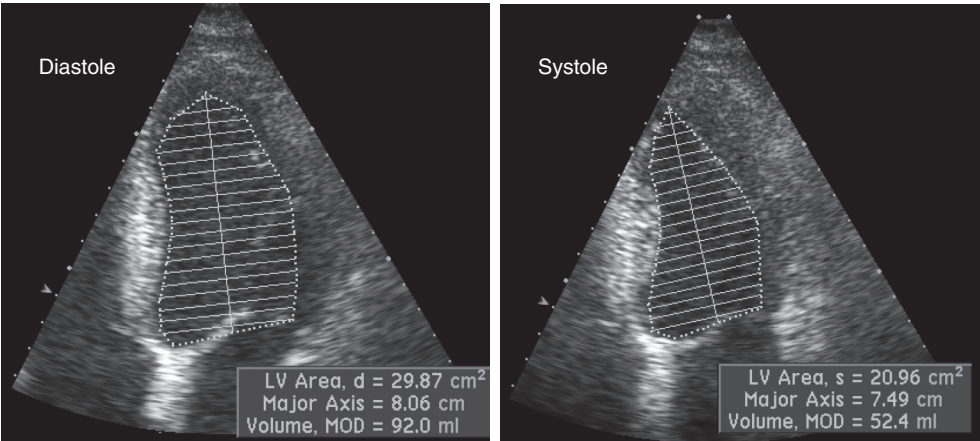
■ Endocardial border tracings of the left ventricle (LV) from the apical four-chamber view during diastole and systole are used to calculate LV volumes. Using concordant LV volume calculations from the apical two-chamber view, ejection fraction is calculated using the apical biplane method of disks algorithm. *Volume, MOD, Calculated LV volume.*
